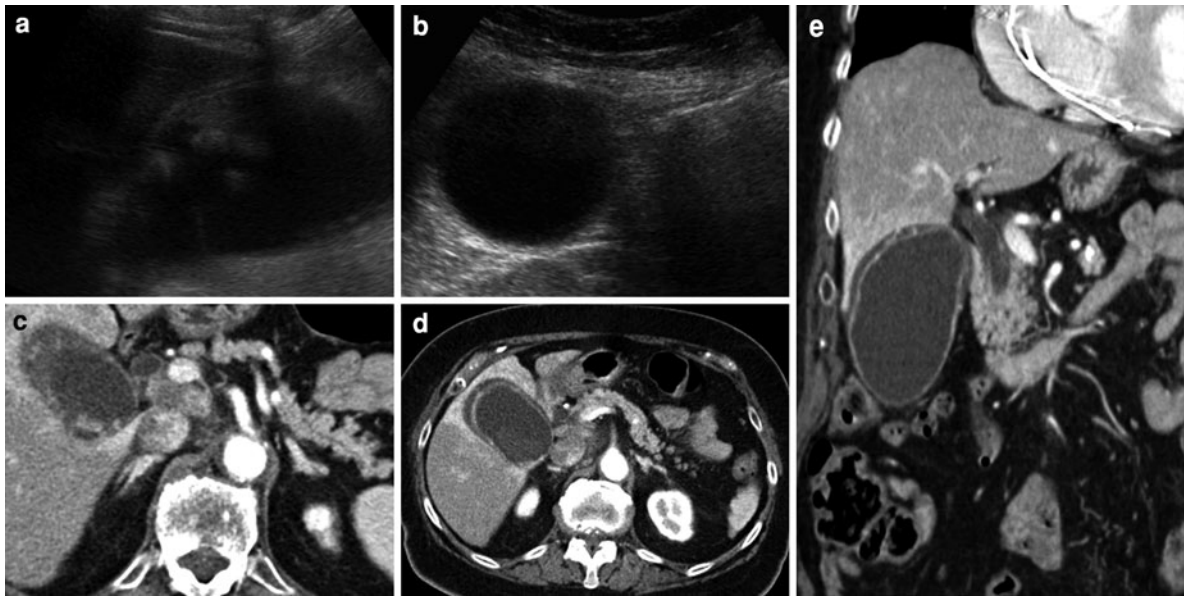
A 88-year-old woman with abdominal pain and a Murphy sign on clinical examination. a Ultraonography (US) findings were misleading because there was some material within the gallbladder but it was “floating”. Shadowing was mild. b No definite wall thickening in the gallbladder fundus. Although the diagnosis of acute cholecystitis was likely, computed tomography (CT) was performed because of some ambiguous features. c–e Postcontrast CT in the axial (c, d) and in the coronal (e) planes. Obvious thickening of the gallbladder
